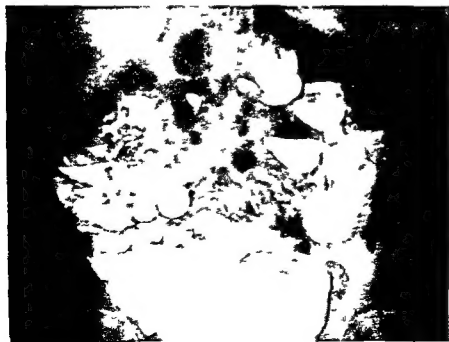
Radiograph multiple diverticula protruding from the small bowel.
